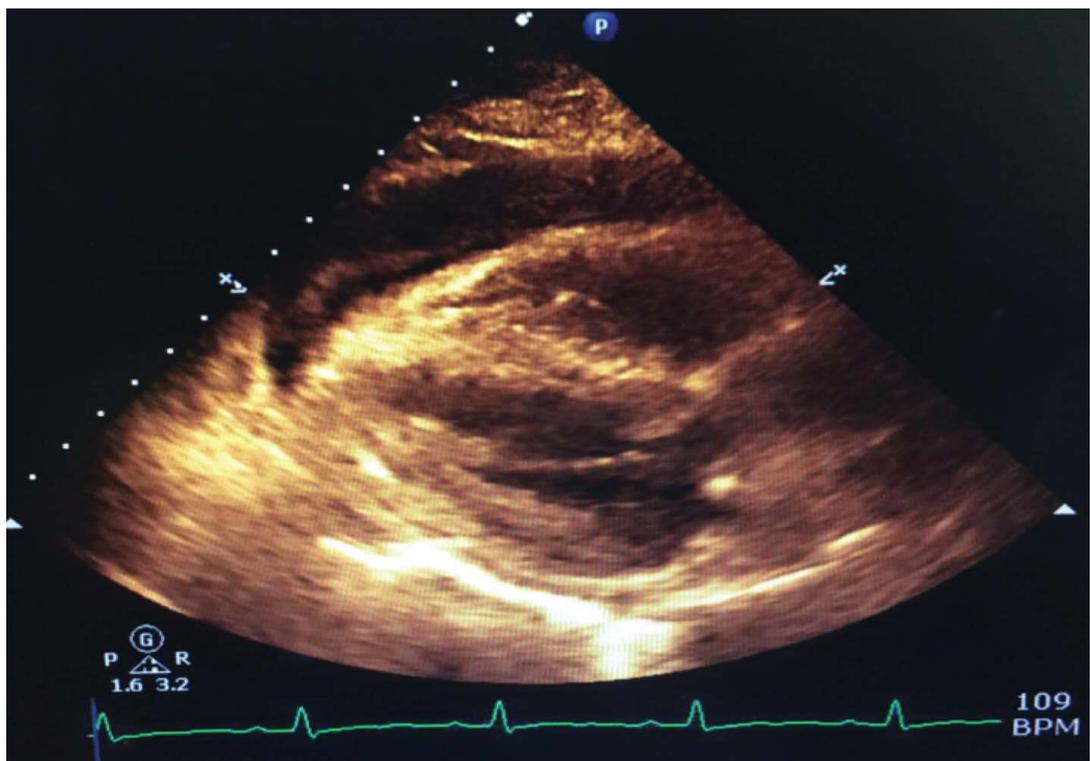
Echocardiography: global thinning of left ventricle.
